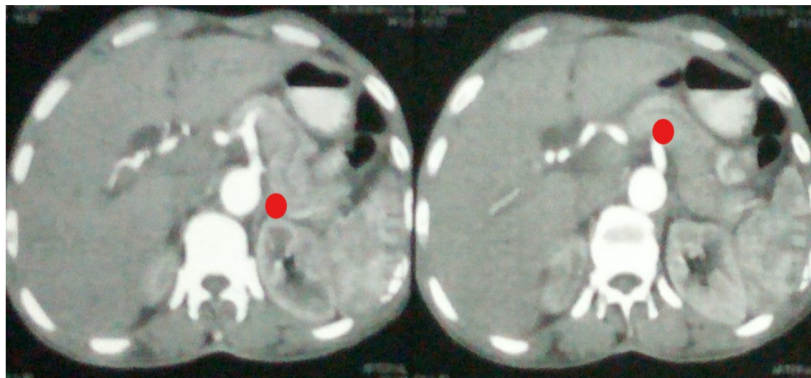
CT pre-operative with red tag on the dilated pancreatic duct.
